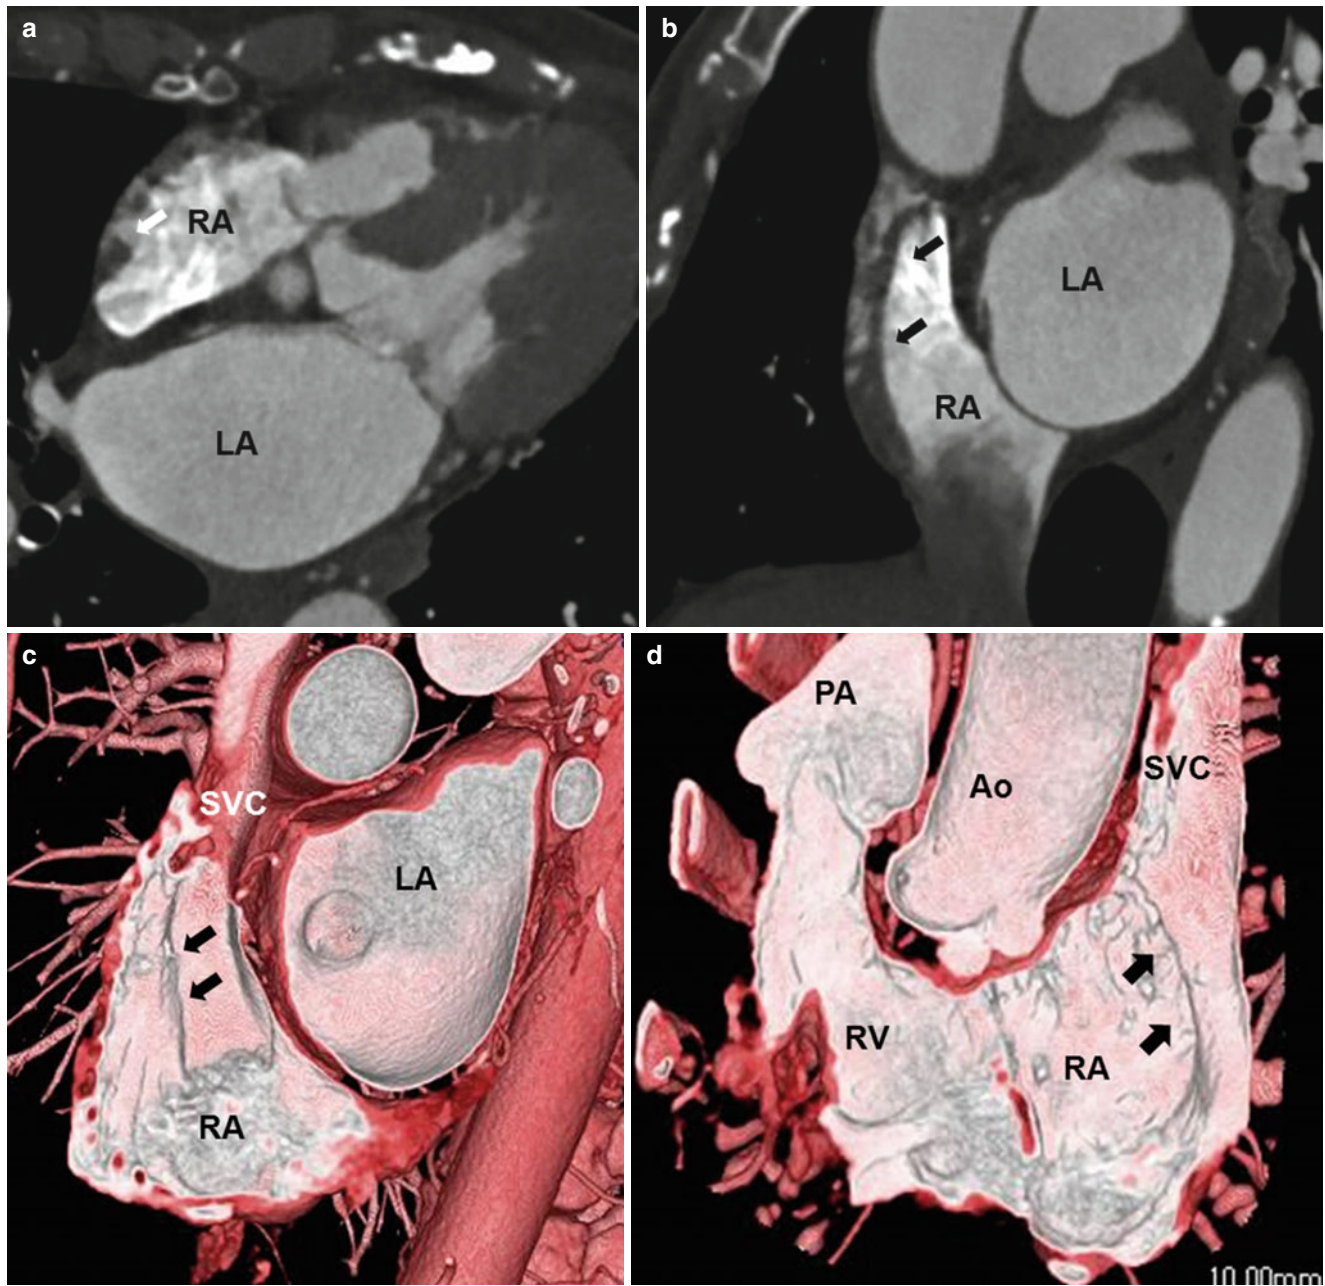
Crista terminalis. Transverse (a), coronal-reformatted (b), and volume-rendered (c, d) CT images show the crista terminalis (arrows) extending from the superior vena cava to the inferior vena
